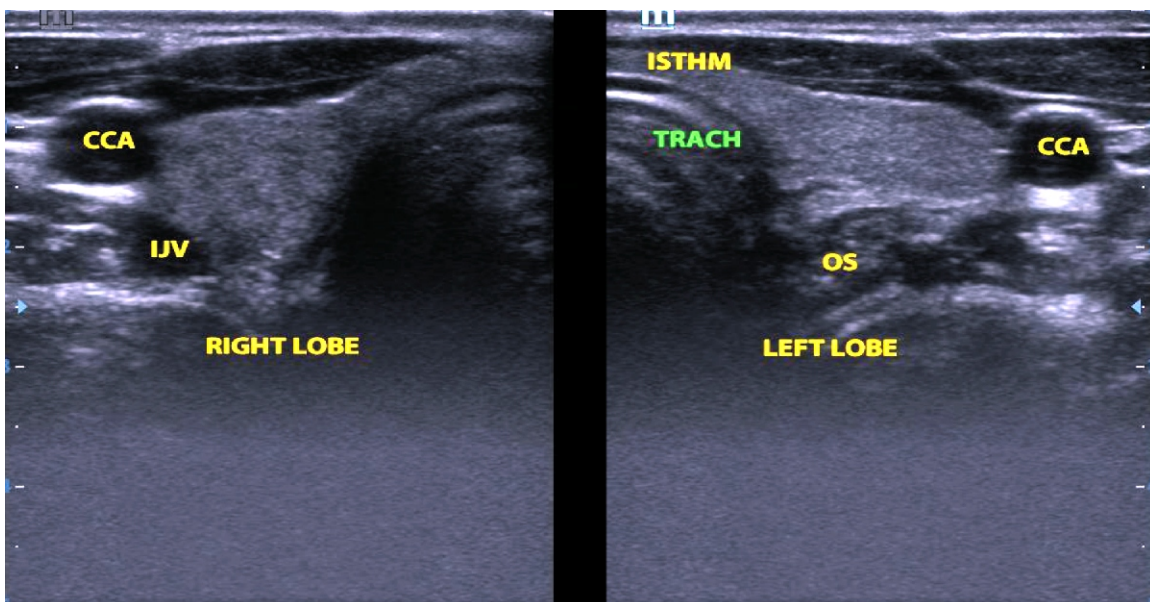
Gray scale transverse ultrasound image of normal thyroid gland and surrounding structures
